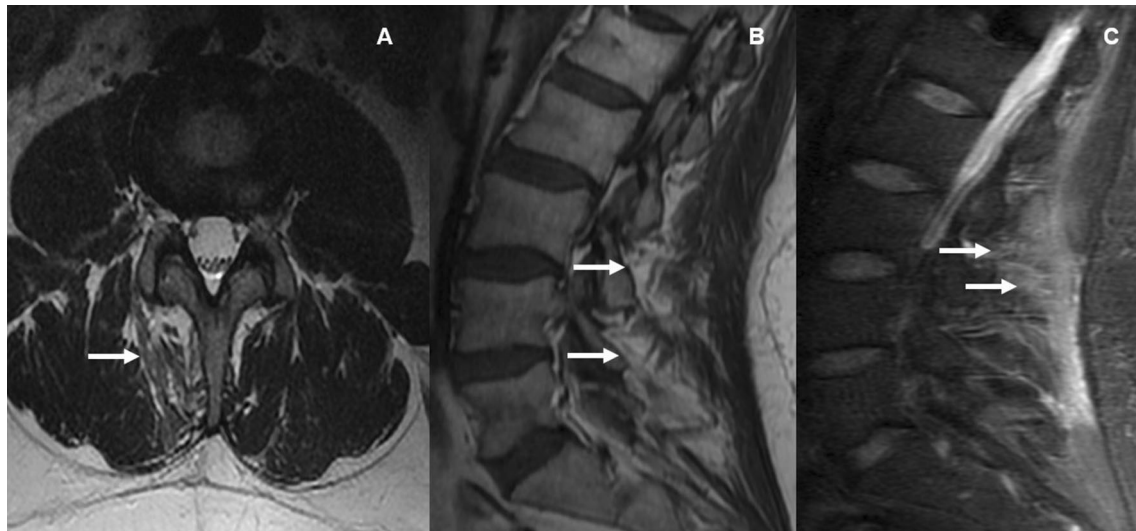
a Axial T2-weighted magnetic resonance imaging (MRI), which demonstrates fat infiltration of the right multifidus muscle. b, c Sagittal T2-weighted MRI imaging
